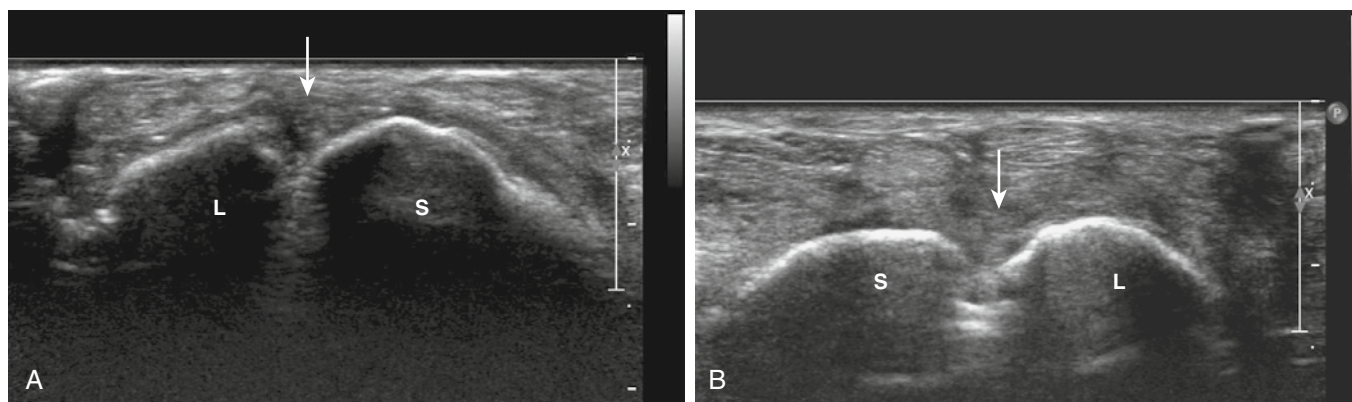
Ultrasound scan of the torn scapholunate ligament (SLL) (A) and an intact packed fibrillar pattern of a normal SLL (B).
